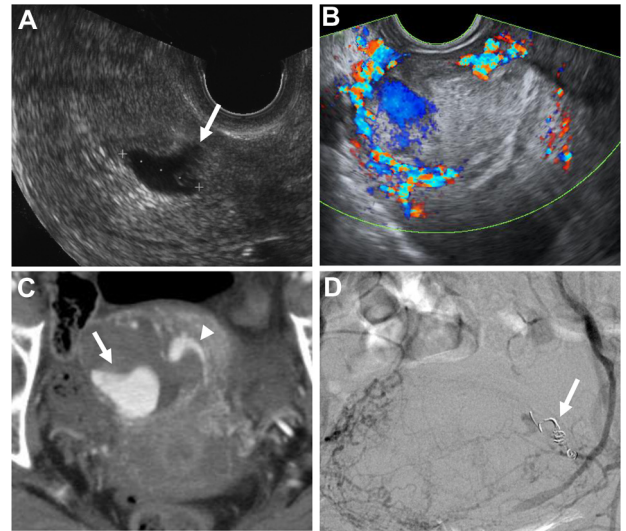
Findings in initial cesarean scar pregnancy. (A) Transvaginal ultrasonography showing the gestational sac at the previous cesarean section scar (arrow) at 7 weeks of gestation before dilatation and curettage performed under the diagnosis of missed abortion. (B) Transvaginal color Doppler ultrasonography showing the retained gestational products with prominent vascular flow at the previous cesarean section scar 7 weeks after dilatation and curettage, leading to the diagnosis of cesarean scar pregnancy. (C) Axial computerized tomographic image of hemorrhagic cesarean scar pregnancy showing the prominent extravasation (arrow) of iodine-contrast media from the left uterine artery (arrowhead). (D) Angiographic finding of cesarean scar pregnancy after intra-arterial infusion of dactinomycin followed by left arterial embolization by platinum coils (arrow).
